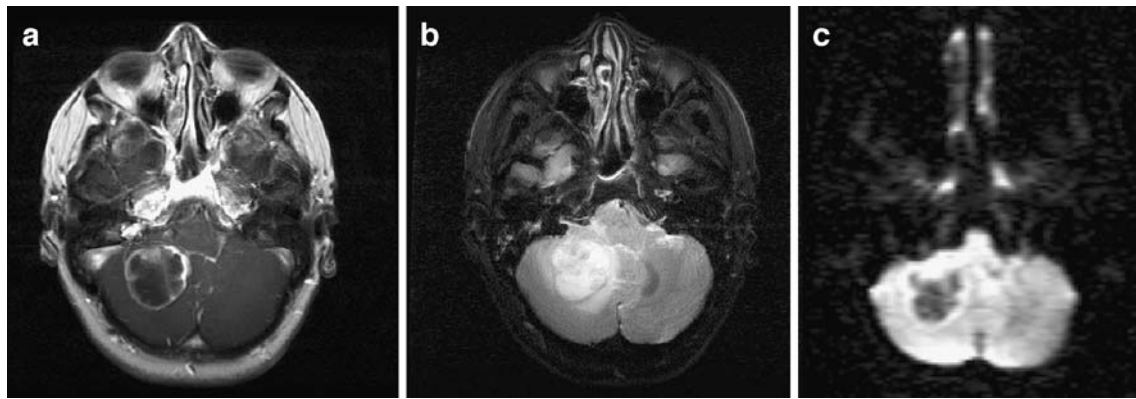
a Metastatic non-small-cell lung cancer as ring-enhancing lesion in the right cerebellum on T1-weighted MR imaging with gadolinium. b Hypointense arc on T2-weighted image, seen
